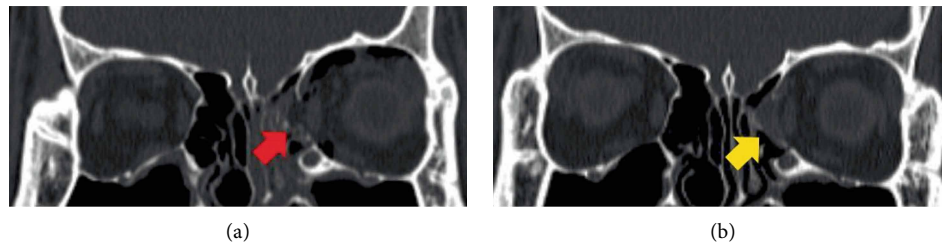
CT images of the case 2 patient. Initial fracture and defect (a, red arrow) was well-reduced by a combination plate of resorbable meshed plate and allogenic bone substitute (b, yellow arrow).
